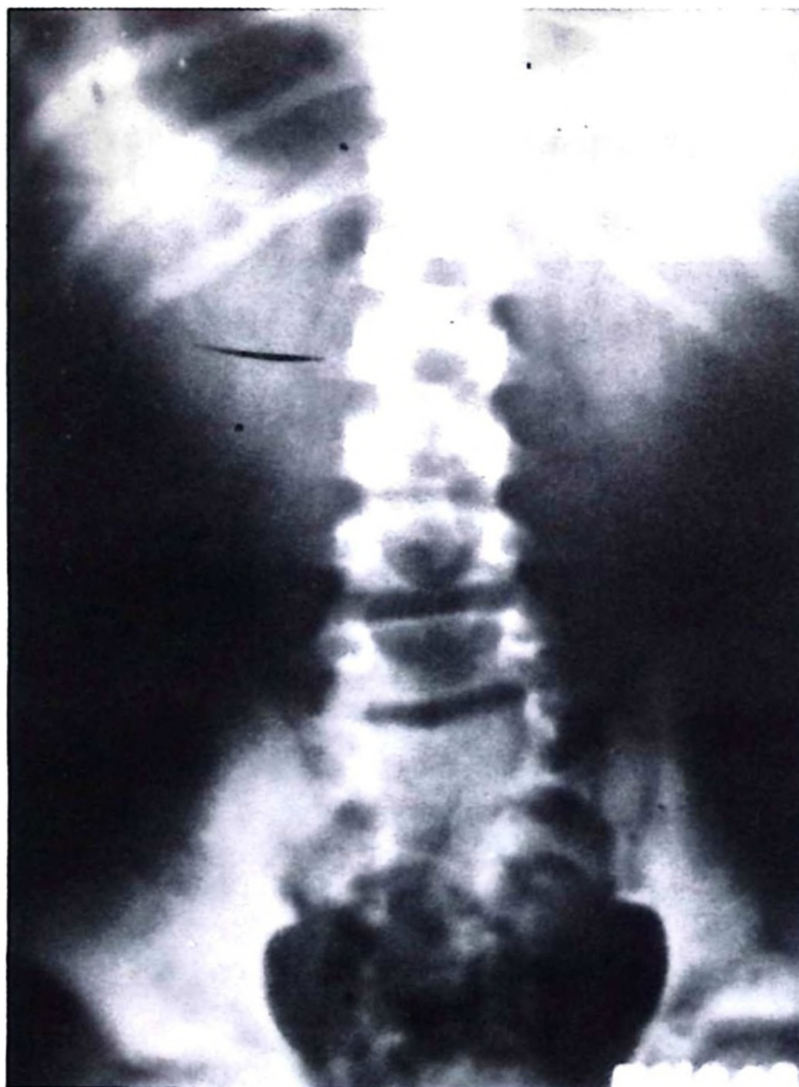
Spina bifida; on direct roentgenogram of lumbosacral region.
